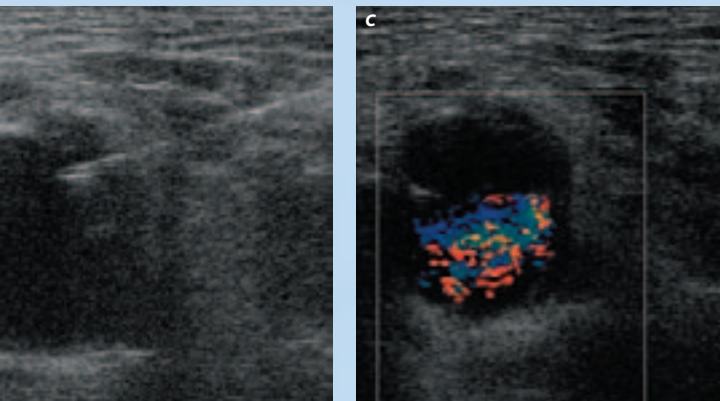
(a) Needle puncturing into the pseudoaneurysm (PA) from the common femoral artery (CFA). (b) The locule furthest from the needle during puncture, as the needle is most conspicuous in this mode. (c) Colour Doppler image showing absence of flow in the locule. This was subsequently punctured and embolised.
